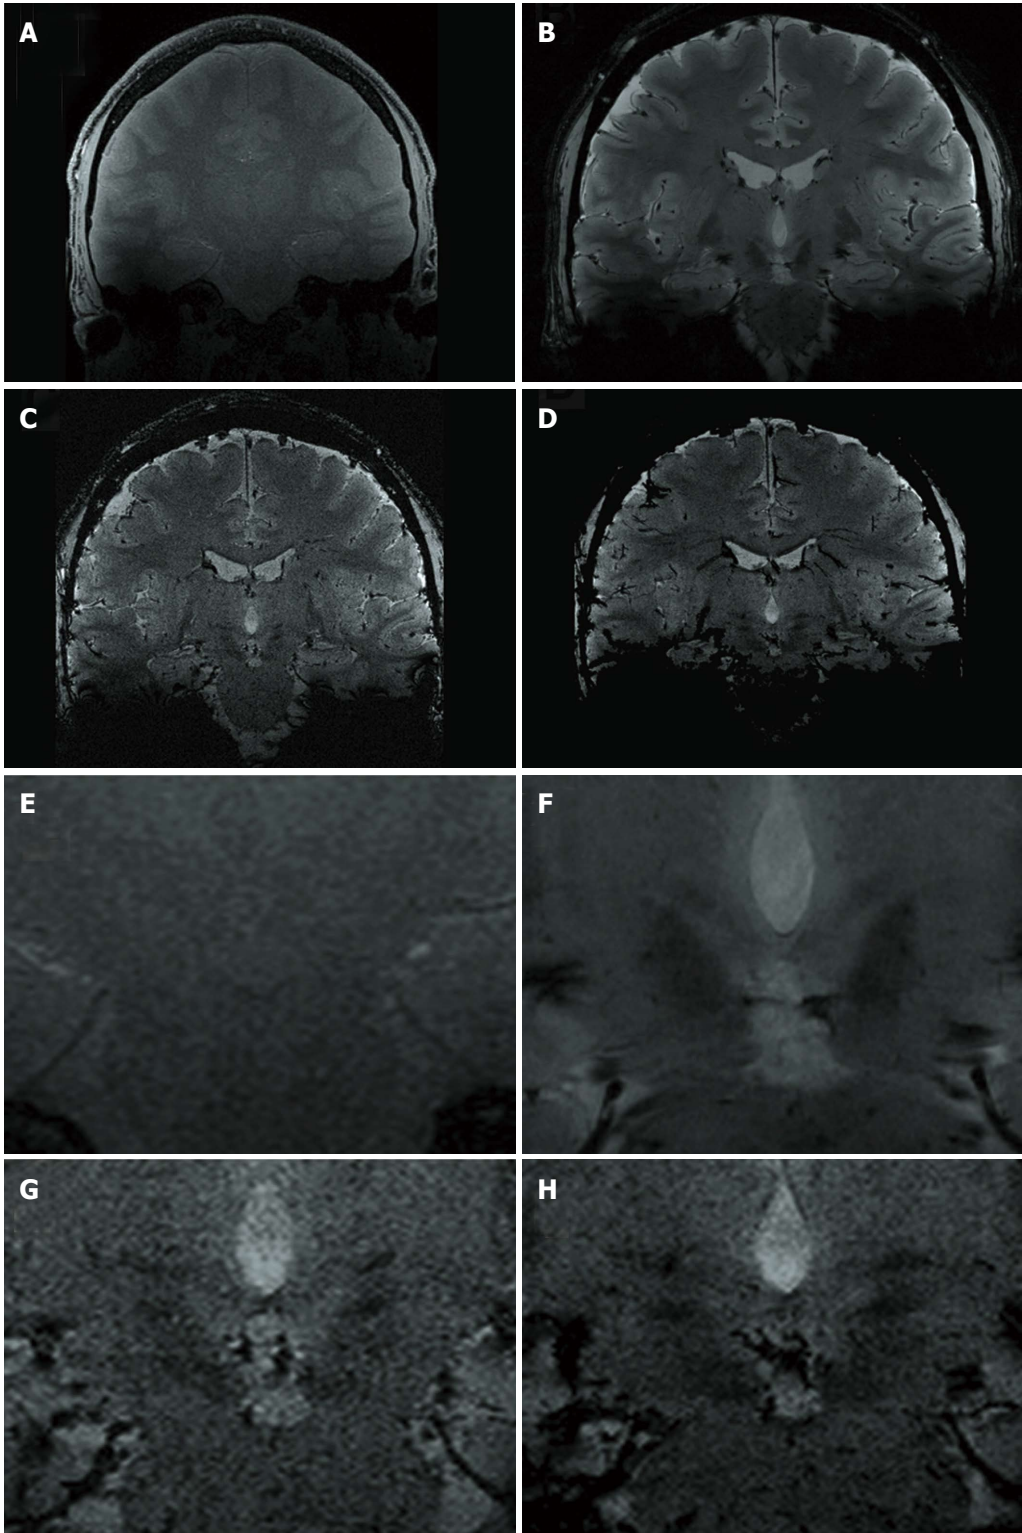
Non-enlarged (A-D) and enlarged (E-H) representative coronal images at the level of the zona incerta. A, E: T1-weighted gradient-echo coronal; B, F: FLASH2D-T2Star coronal; C, G: Susceptibility-weighted imaging (SWI) coronal; D, H: SWI-minimum intensity projections coronal.
